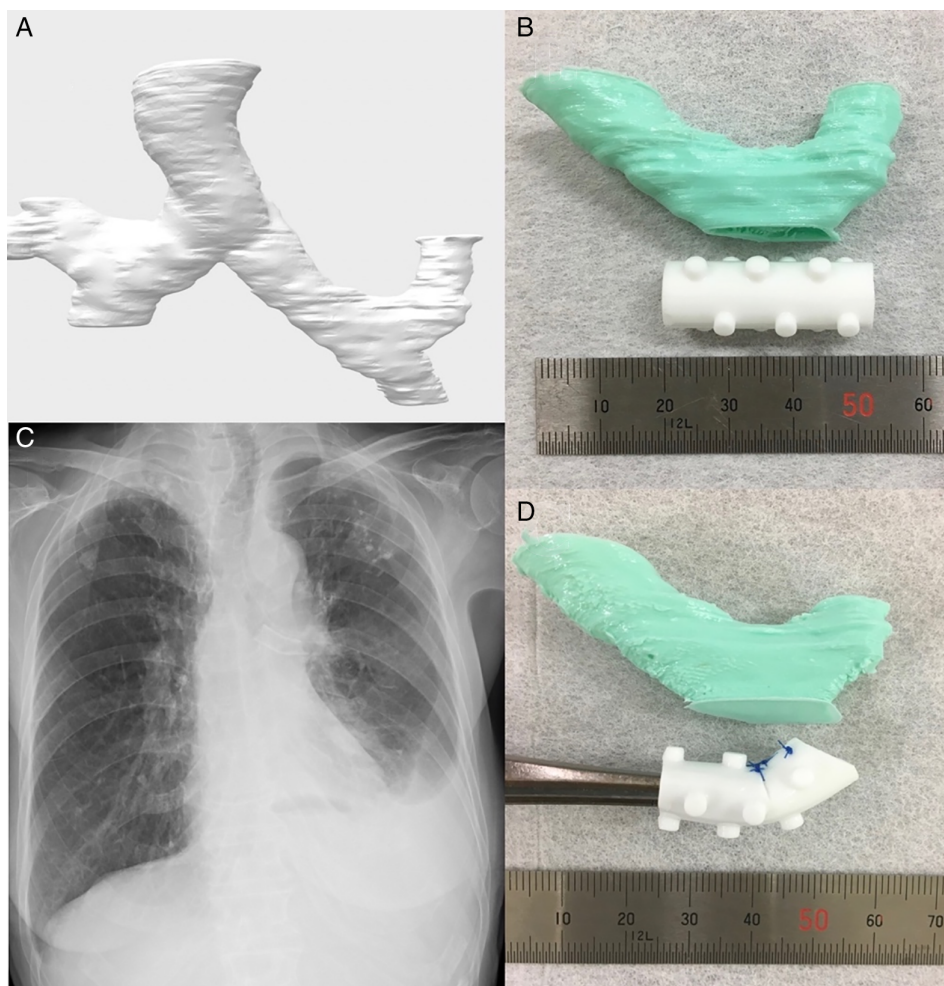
(A) Three-dimensional (3D) model of the patient's bronchial wall using converted STL-format data for 3D printing. (B) A 10-mm ready-made Dumon stent. (C) The stent is modified to bend with a length of 30 mm and a tapering point. (D) Chest X-ray showing that the stent is able to maintain left upper lobe airway patency.
